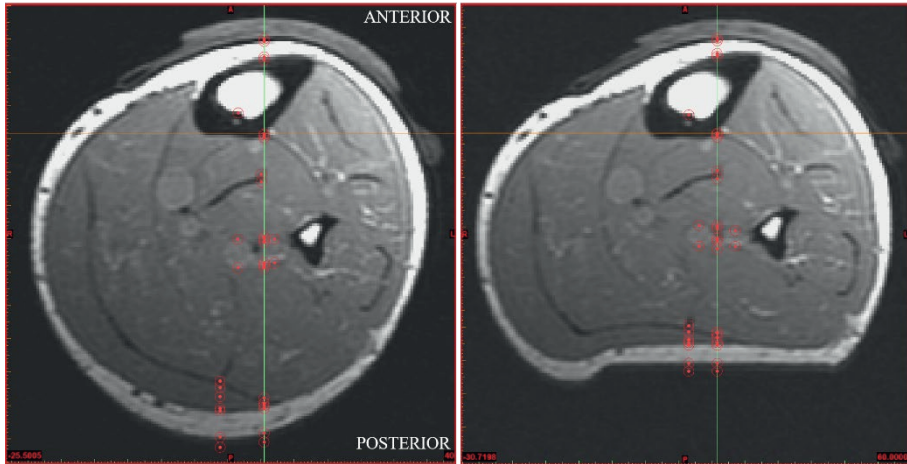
Corresponding MR images with identified tissue reference points as red dots in circles. The local coordinate system is displayed by orange line for x-axis, green line for y-axis, intersecting at the defined origin. Left: Non-loaded. Right: Loaded, indenter applied. Additional points medial and lateral to the y-axis are displayed, along parallel $y(x(n))$ axes.
